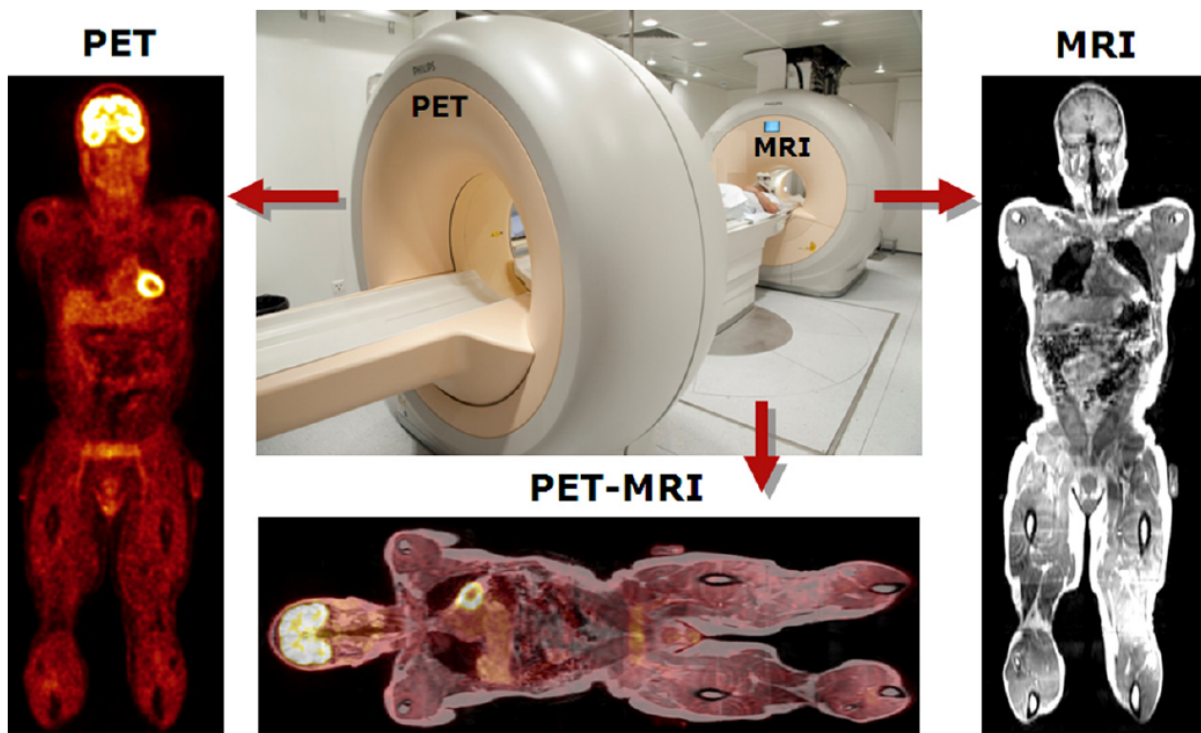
The sequential PET/MR scanner of the Philips whole-body Ingenuity system at Geneva University Hospital with MR, PET, and PET/MR images. Adapted from [92].
